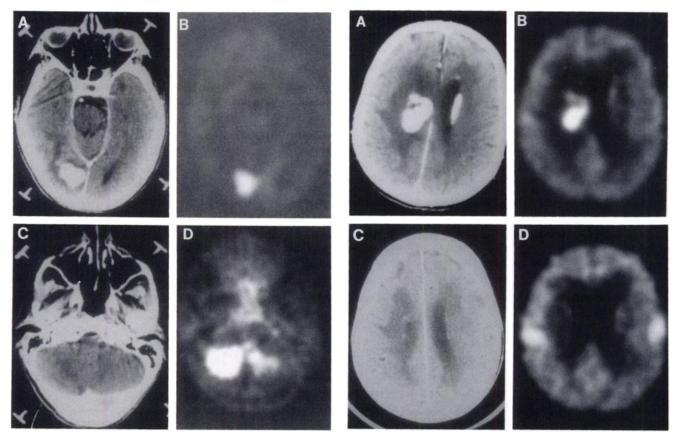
Contrast-enhanced CT (A,C) and FDG-PET (B,D) scans of a 78-yr-old female (Patient 9) with PCNS-L. The CT scan through the cerebellum (C) shows no abnormalities, although the FDG-PET scan (D) shows markedly decreased FDG accumulation in the cerebellar hemisphere contralateral to the patient's tumor.
